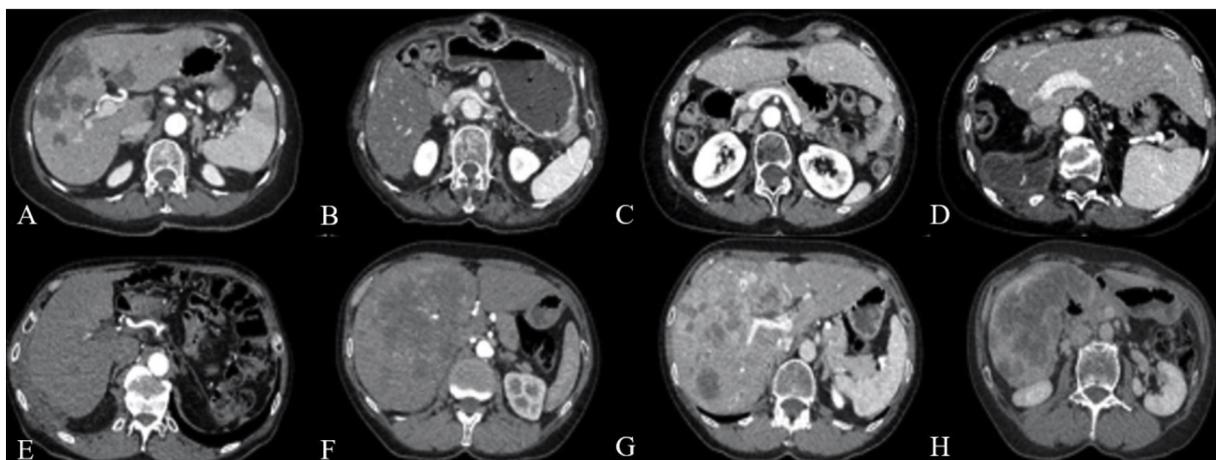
Examples of images obtained with the two CT protocols investigated. A–D SBP A: Parenchymal contrast enhancement (CE) showing hypoattenuated liver metastases; B: Simultaneous CE of aorta, portal vein, superior mesenteric artery (SMA), and superior mesenteric vein; C: CE of aorta, vena cava, SMA, and renal veins; D: Simultaneous CE of aorta and portal vein; E–H MPP E/F: Hepatic arterial phase G: Portal venous phase; H: Delayed phase.
